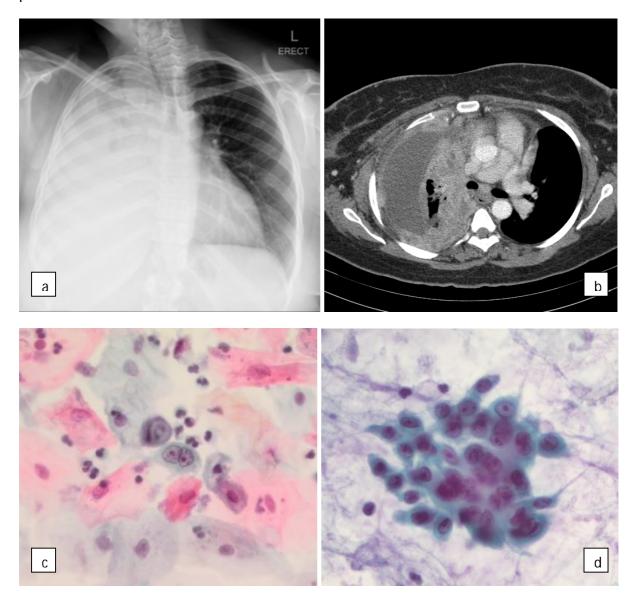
Right lung collapse with ipsilateral pulmonary nodules on chest X-ray (a) and CT (b). Sputum - malignant. Cells had prominent nucleoli with marked clumping and clearing of chromatin. Cytoplasm appeared dense (c). TTNA - Squamous cell carcinoma, non-keratinising (d).
